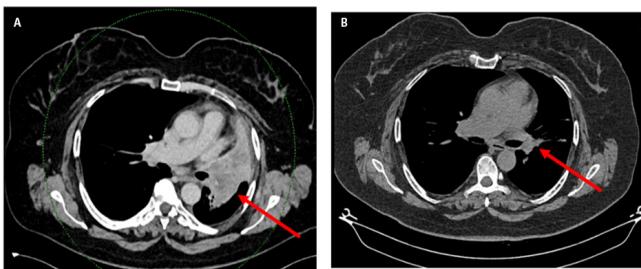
Thoracic computed tomography, (A) Before crizotinib: A right hilar mass (red arrow), likely representing a tumor or lymph node enlargement, causing partial compression of adjacent structures. (B) After crizotinib: Significant reduction in the size of the right hilar mass (red arrow), indicating a positive therapeutic response.
